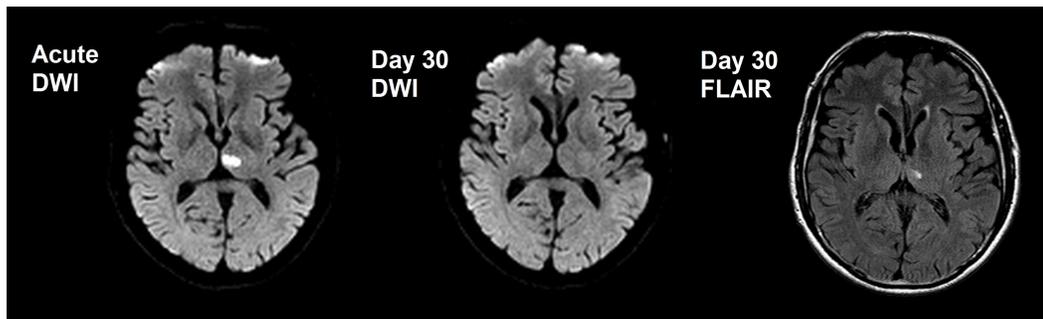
Acute MRI demonstrates a small ischemic DWI lesion, which is seen to resolve by day 30. A small lesion can also be seen as bright signal intensity on they day 30 FLAIR sequence in the corresponding area.
